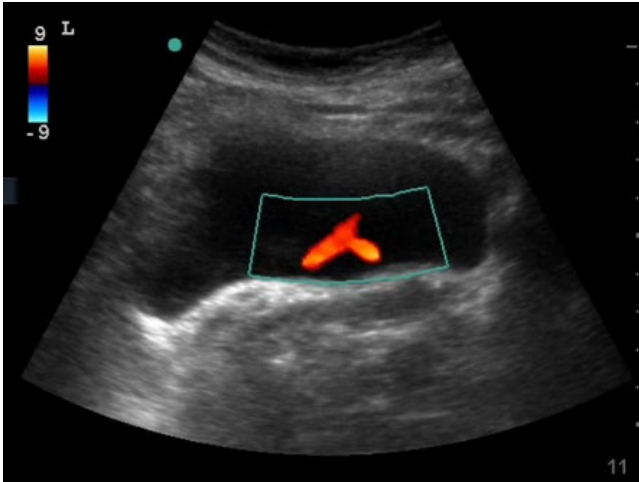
Bilateral ureteral jets. Note that the colour Doppler window is appropriately adjusted to be small (to avoid low frame rates), and the velocity scale is also set low ($\pm 9 \text{ cm s}^{-1}$) to pick up low-flow signals. The overall depth setting is unnecessarily deep. Figures © A. J. Dean.
